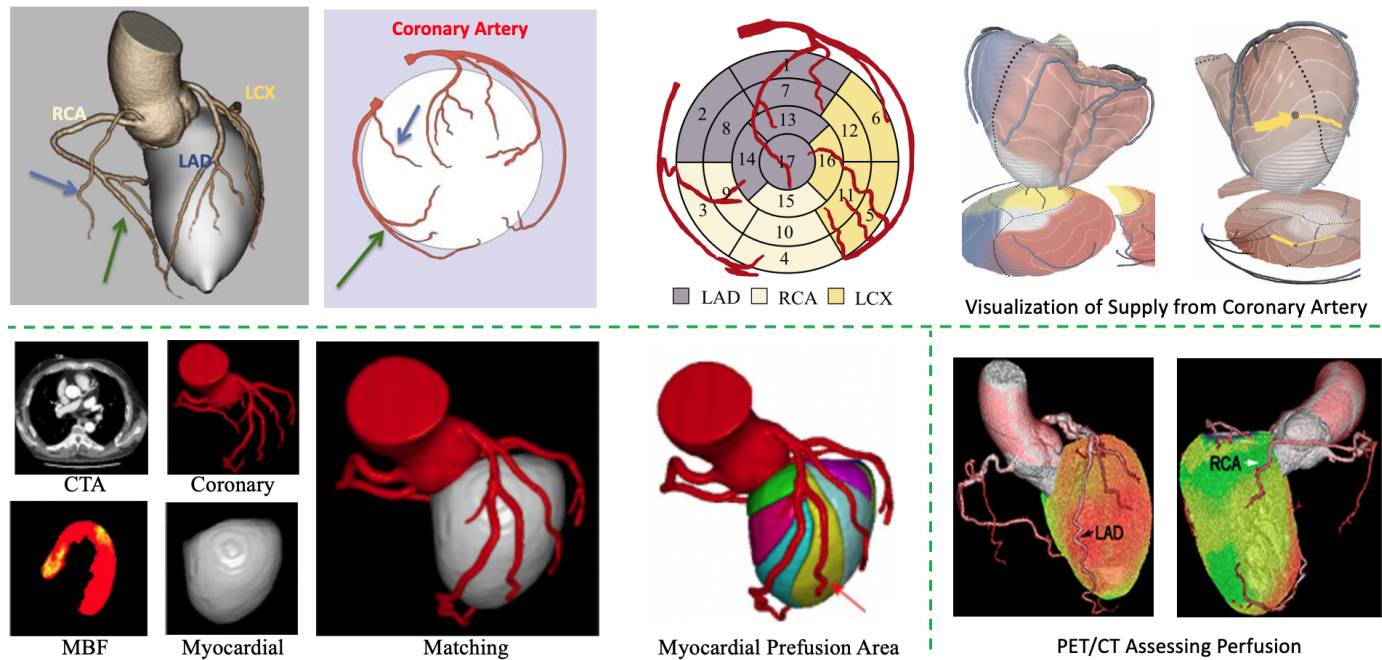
Examples of connections of non-vessel and vessel structures. Top: An relation example of the Coronary Artery with corresponding LV regions for providing blood. (LAD: left anterior descending; RCA: right CA; LCX: left circumflex) [3], [177] and Visualization of Myocardial Perfusion from Coronary Anatomy [178]. Bottom (left): Determination of Myocardial Perfusion Territory [179]. Bottom (right): PET/CT assessing perfusion and Coronary Artery anatomy [180].
